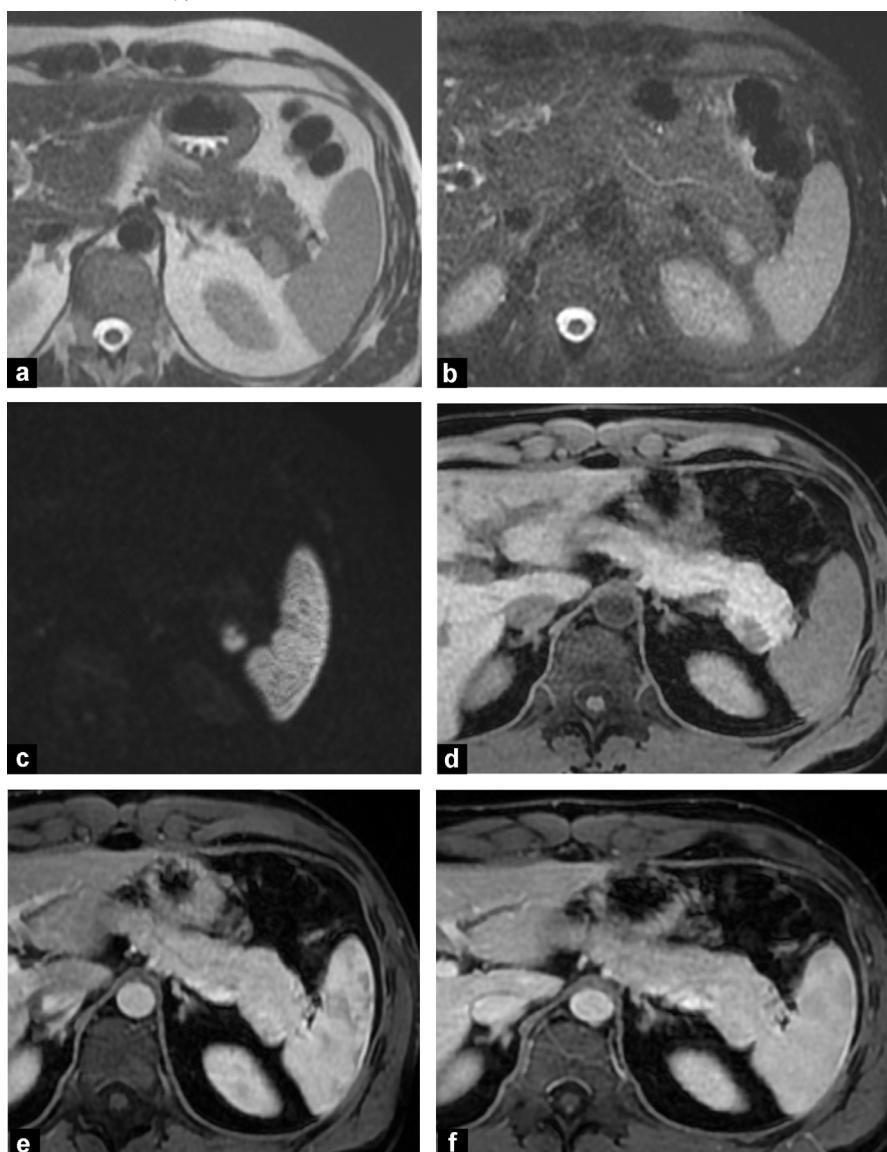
Intrapancreatic accessory spleen mimicking a pancreatic endocrine tumor. T2-weighted MR images without (a) and with (b) fat suppression show a hyperintense small lesion located in the pancreatic tail. On diffusion-weighted MR image with high b value ($b = 1000$), the lesion appears hyperintense. On T1-weighted dynamic sequence before (d) and after injection of contrast at the arterial (8) and venous (8) phase, the lesion enhances. The diagnosis is suggested by the similar intensity of signal of the lesion compared to the spleen in all sequences.
